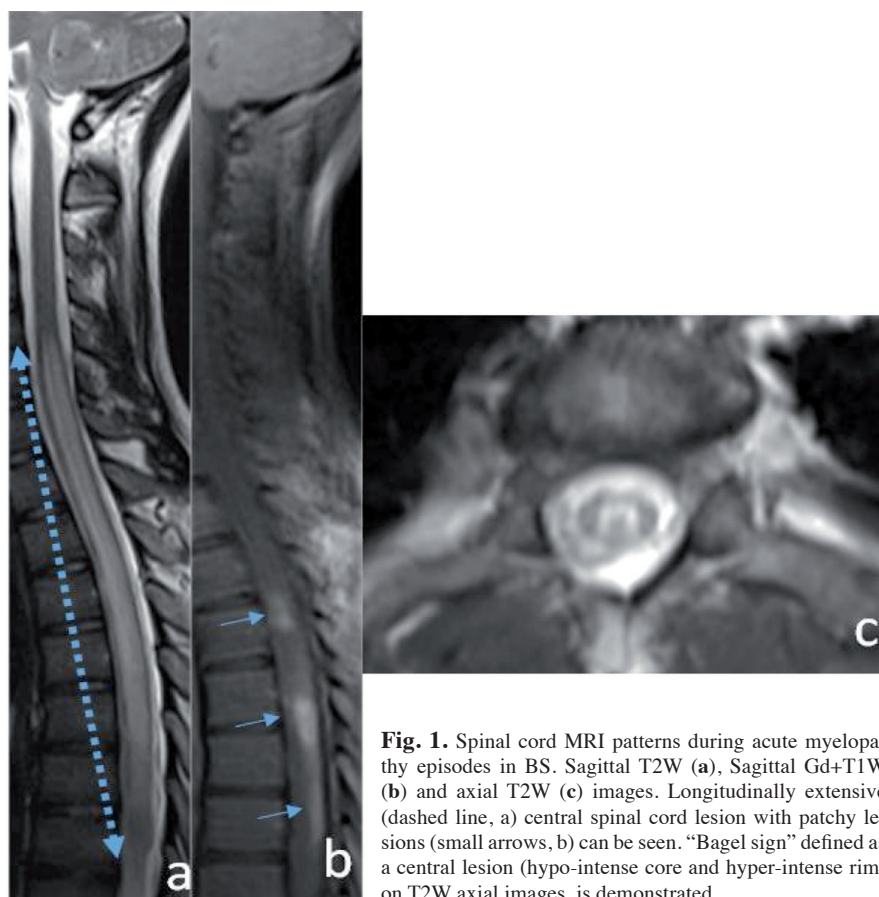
Spinal cord MRI patterns during acute myelopathy episodes in BS. Sagittal T2W (a), Sagittal Gd+T1W (b) and axial T2W (c) images. Longitudinally extensive (dashed line, a) central spinal cord lesion with patchy lesions (small arrows, b) can be seen. “Bagel sign” defined as a central lesion (hypo-intense core and hyper-intense rim) on T2W axial images, is demonstrated.
